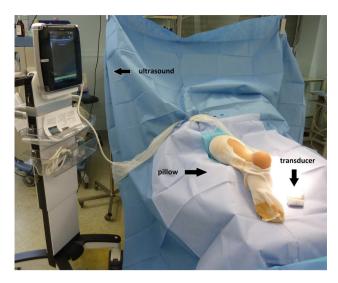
The patient is in the prone position with a pad under the ankle. Note the ultrasound machine and transducer.
